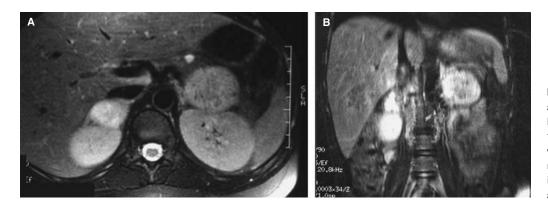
Pheochromocytoma in a 16-year-old male who presented with low-grade fever, recent weight loss, tachycardia, and hypertension. (A) Transverse MRI image showing the tumor mass in the left adrenal. (B) Coronal MRI image showing the tumor in the left adrenal gland above the kidney.
